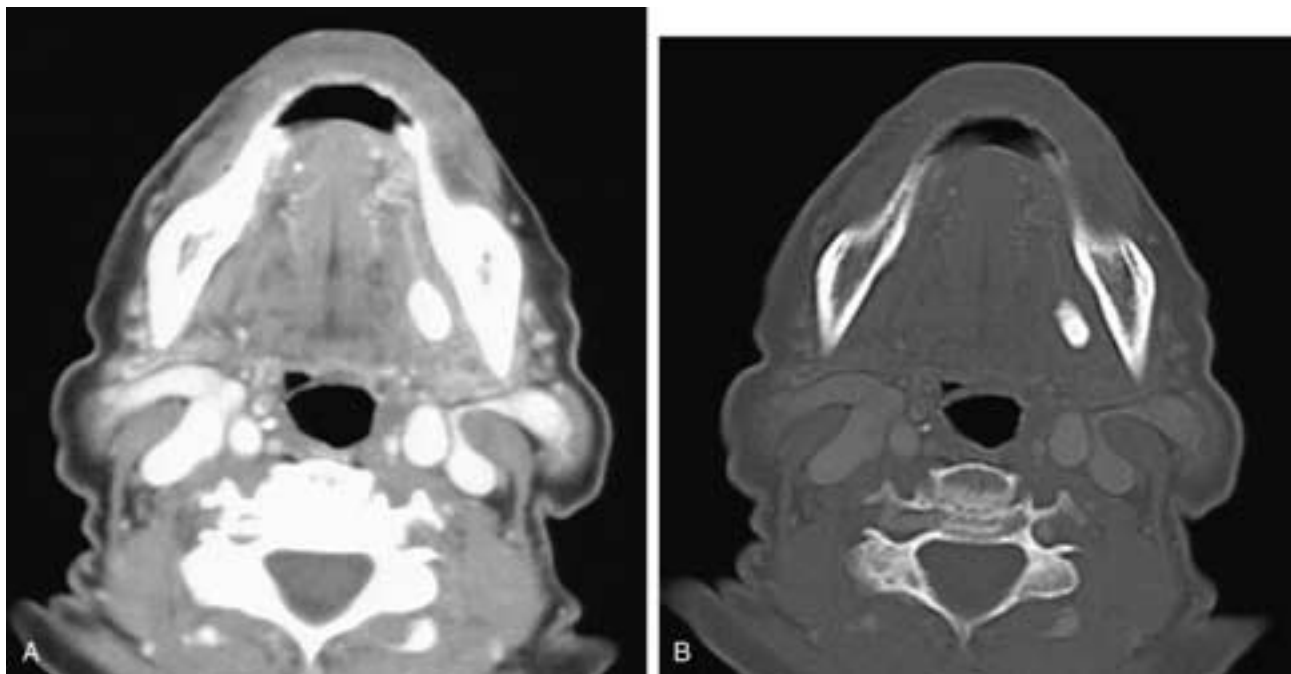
Axial CT scans viewed at narrow (A) and wide (B) windows show a calculus in the left hilum and the proximal portion of Wharton's duct. This patient had submandibular sialolithiasis and early sialadenitis.
